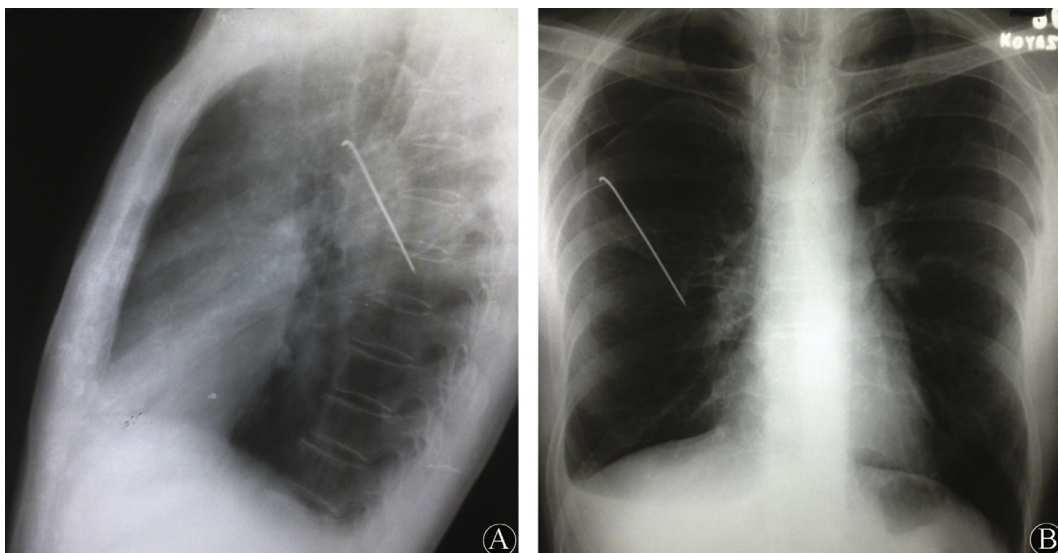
A and B. Radiograph showing full length of migrated bend K-wire in lateral and anteroposterior views.
